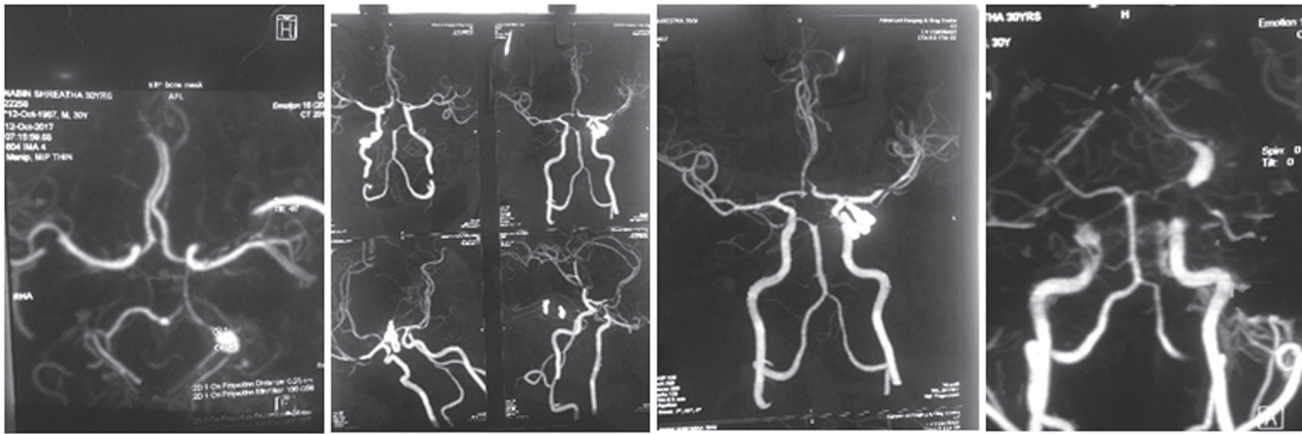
Preoperative cerebral CT Angiogram showing fusiform aneurysm at P2A segment of PCA
